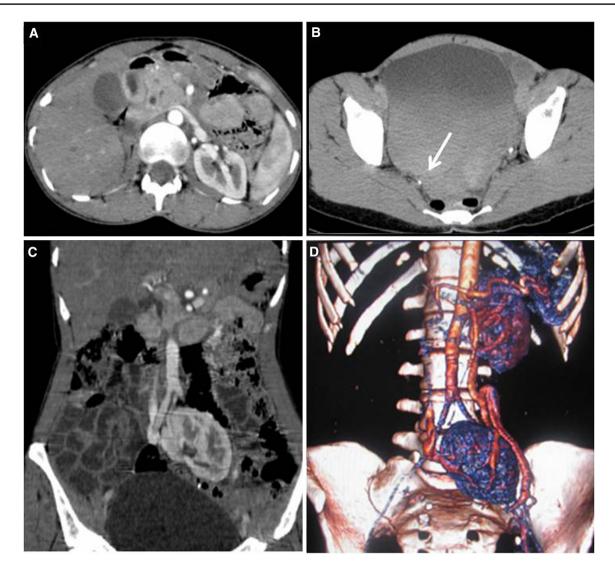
Cross unfused kidney (Type B crossed ectopia). An axial post contrast CT image (a) shows empty right renal fossa. An axial image (b) shows the ureter of the ectopic kidney crossing to the contralateral side. A coronal reformatted image (c) shows the crossed
